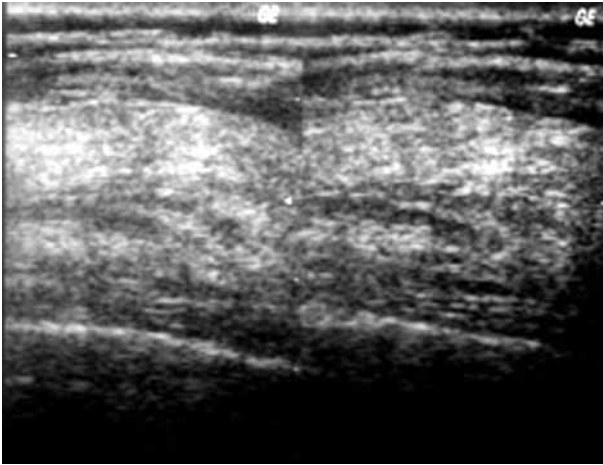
Ultrasound examination of the right scapular area shows an oval soft tissue mass located behind the ribs. Its echogenicity is slightly heterogeneous, with hyperechoic streaks along the great axis of the mass.
